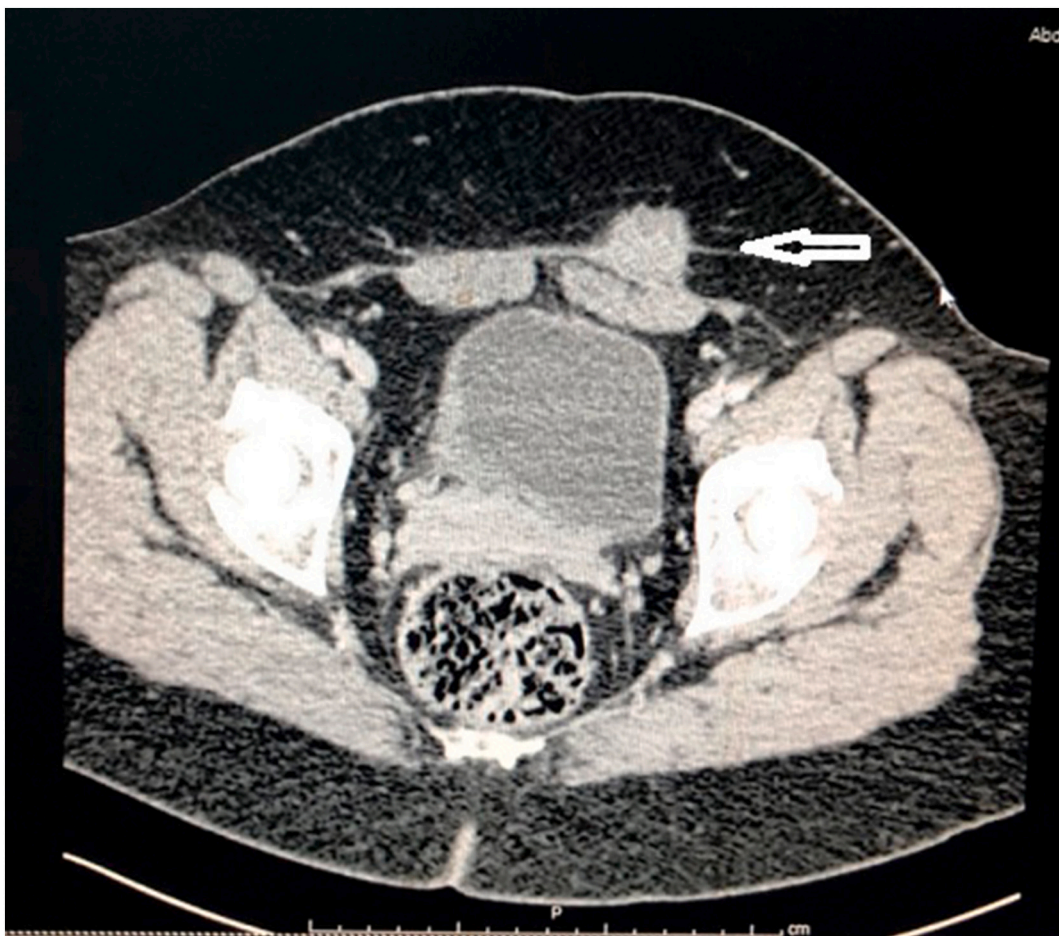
The image shows an abdomen pelvis contrasted CT scan, white arrow points to the endometrial tissue implanted in the abdominal wall close to a previous C-section scar.
